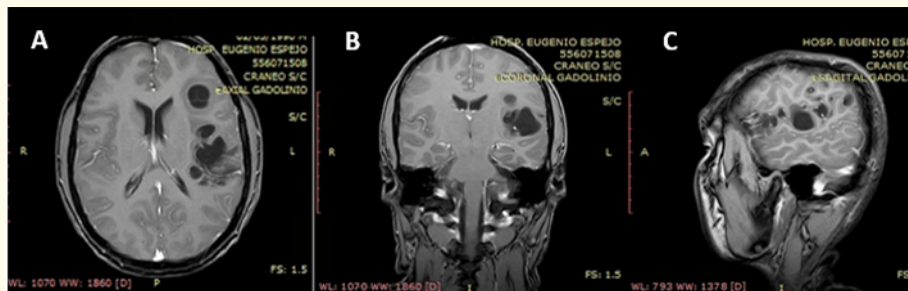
Brain contrast-enhanced MRI. A: Axial view; B: Coronal view; C: Sagittal view.
